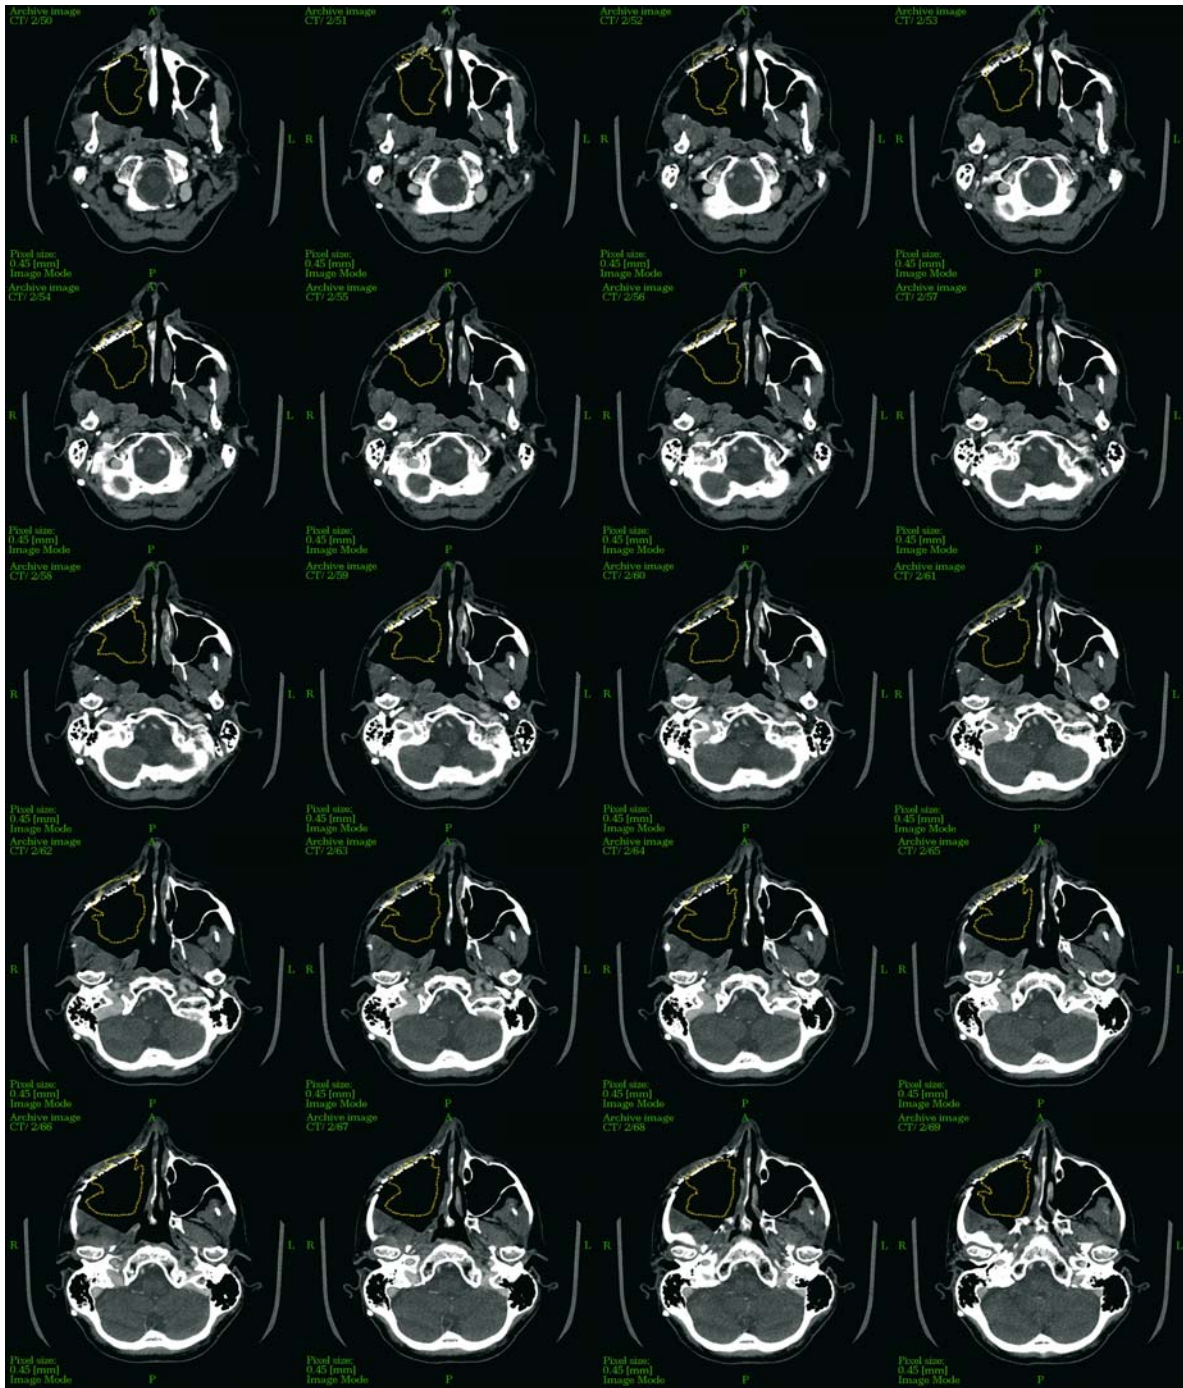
Postoperative evaluation of the resection and radiotherapy planning. Transferring the tumor boundaries from the preoperative to the postoperative CT data set (yellow line) is
